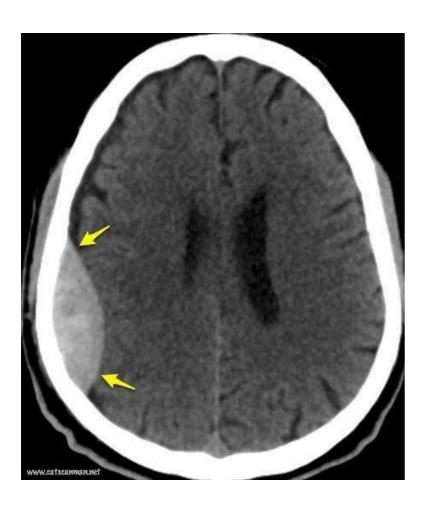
showing CT image of right parieto temporal extradural hemorrhage.
